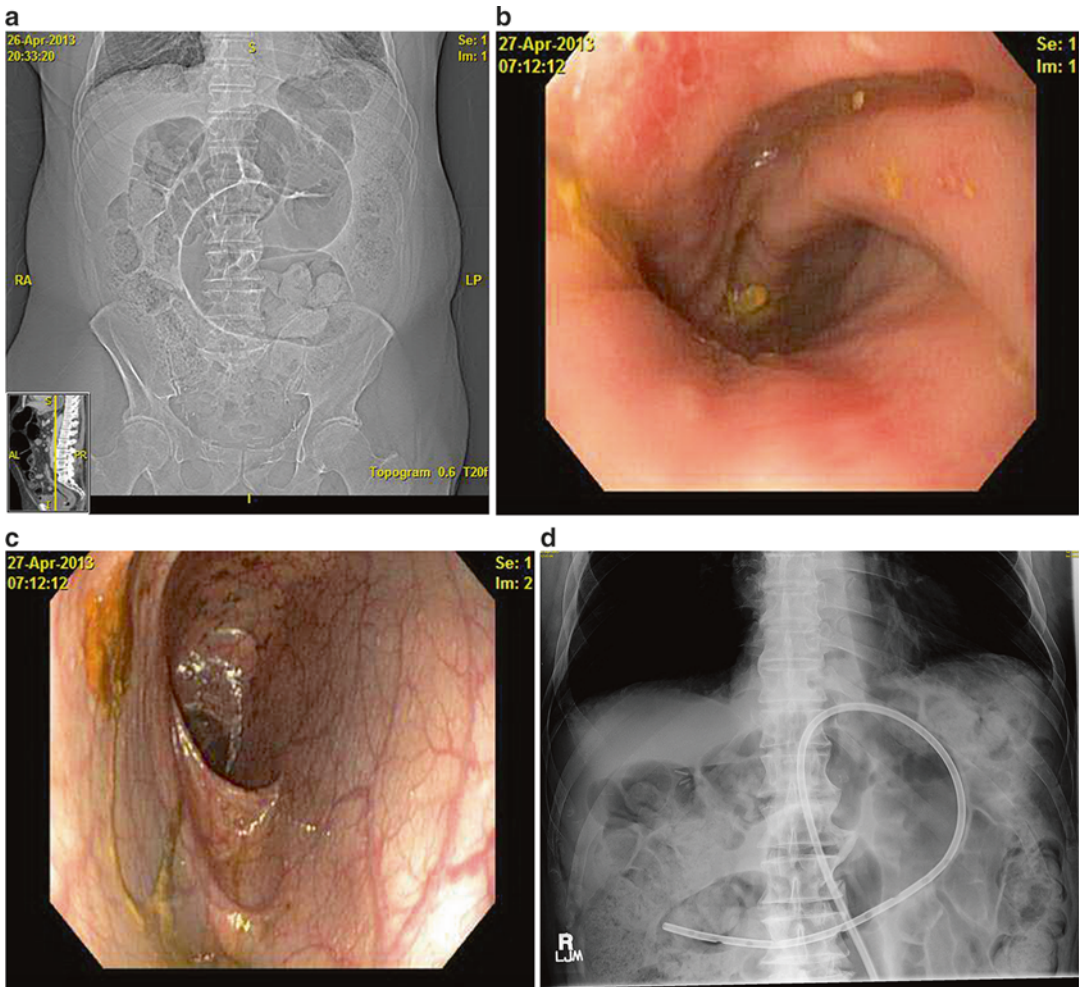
(a) CT topogram showing sigmoid volvulus. (b) Endoscopic view of point of torsion. (c) Advancement of the endoscope into a significantly dilated sigmoid colon
